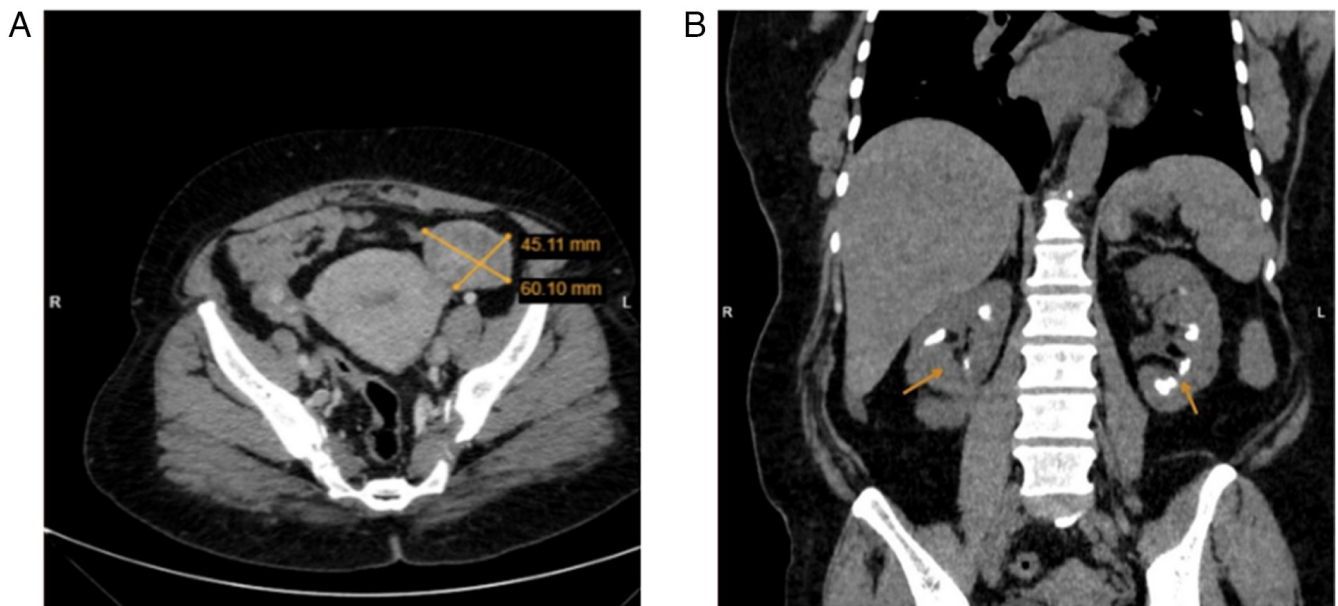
Contrast-enhanced CT images. (A) Axial post-contrast CT scan demonstrating a heterogeneously enhancing complex cystic lesion in the left adnexa, measuring 60x45 mm, consistent with metastatic involvement from primary invasive lobular carcinoma of the breast. (B) Coronal non-contrast CT scan showing multiple hyperdense calcific foci in the medullary regions of both kidneys, consistent with medullary nephrocalcinosis. CT, computed tomography.
